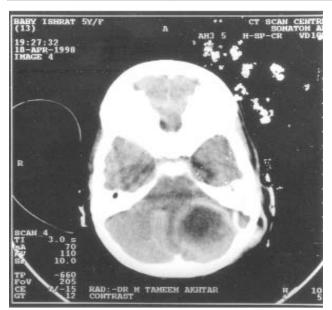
Pre-operative CT scan with contrast (patient 1) shows ring enhancing left cerebellar lesion adjacent to temporal bone with sclerosis of the mastoid air cells.
